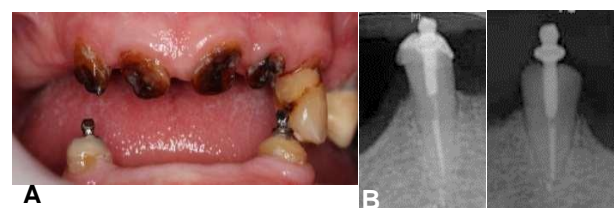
Anterior view of the mouth showing presence of carious anterior teeth and worn down lower studs on teeth 33 and 43; B Radiograph showing lower anterior teeth of 33 and 43.
